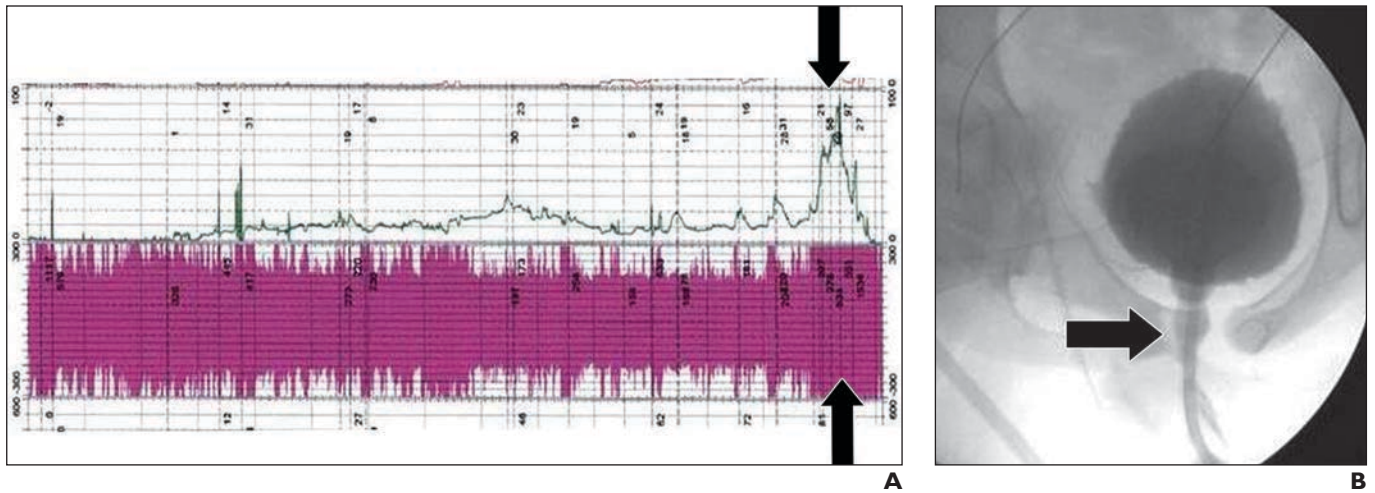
9-year-old girl who presented with chronic wetting and constipation. Videourodynamic study revealed high voiding pressure of nearly 100 cm H₂O. A, Electromyogram shows very active pelvic floor (arrows). B, Activity detected at electromyography correlated with simultaneous firing of external sphincter (arrow) noted on fluoroscopic image. Multiple rounds of biofeedback failed; continence was ultimately achieved with regimen of clean intermittent catheterization. Before initiation of this aggressive approach, patient underwent MRI of urinary tract and lumbar spine to rule out tethered cord. This case is less severe form of Hinman syndrome.
